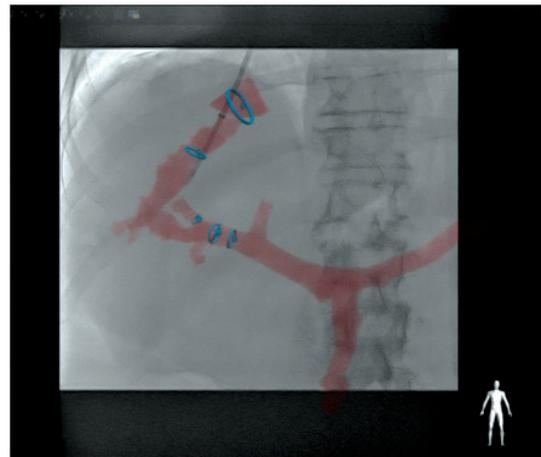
CT guided fusion imaging assisting TIPSS insertion
